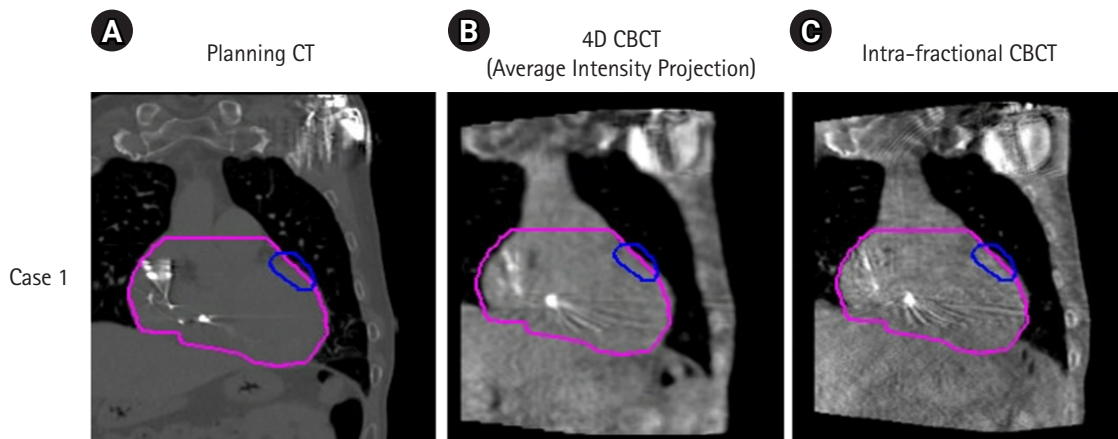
Cone-beam computed tomography (CBCT) image acquisitions for image-guided radiation therapy for ventricular tachycardia stereotactic ablative body radiotherapy of the first patient case: (A) planning CT image, (B) 4D CBCT image, and (C) intra-fractional CBCT image. 4D, four-dimensional.
